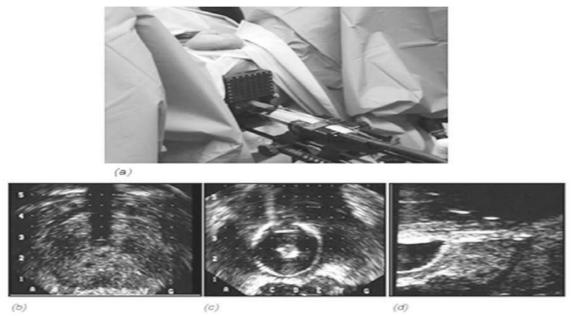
Patient is placed an lithotomy position and draped.(Fig. 2a) Sonographic images showing the urethra at the center of the grid(Fig. 2b) as well as images of the prostato-veiscal junction(Fig. 2c and 2d)
